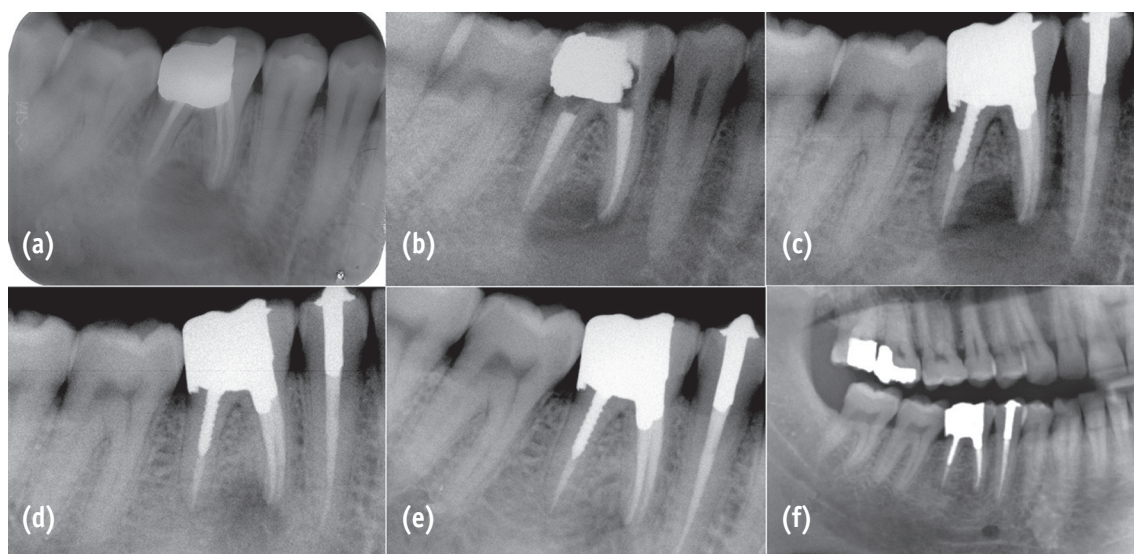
(a) Preoperative radiograph showing a large periapical lesion with loss of lamina dura surrounding the mesial root of lower first molar; (b) Nonsurgical endodontic retreatment was carried out for involved molar but sign/symptoms did not resolve; (c) Pulp Vitality test revealed that the intact adjacent premolar was nonvital and nonsurgical endodontic treatment was carried out; (d, e) Six- and 12-month follow-up radiographs showing gradual bone healing; (f) Two-year follow-up radiograph reveals complete bone healing.
